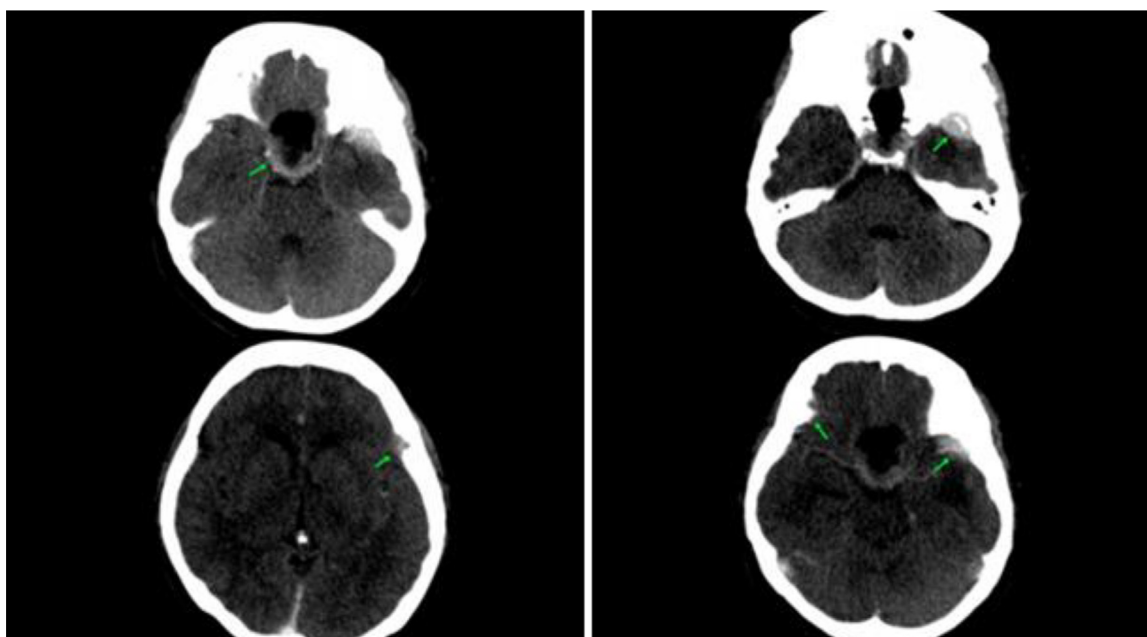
(A) We conducted an axial brain CT scan examination using contrast after undergoing transsphenoidal surgery. A leftover mass was discovered in the sellar area, and several solid lesions outside of the axes were found in both the left frontal and temporal lobes, showing a lot of uniform enhancement. (B) A bone window head CT scan revealed defects and hyperostosis in the left frontal bone and bilateral sphenoid wing.
